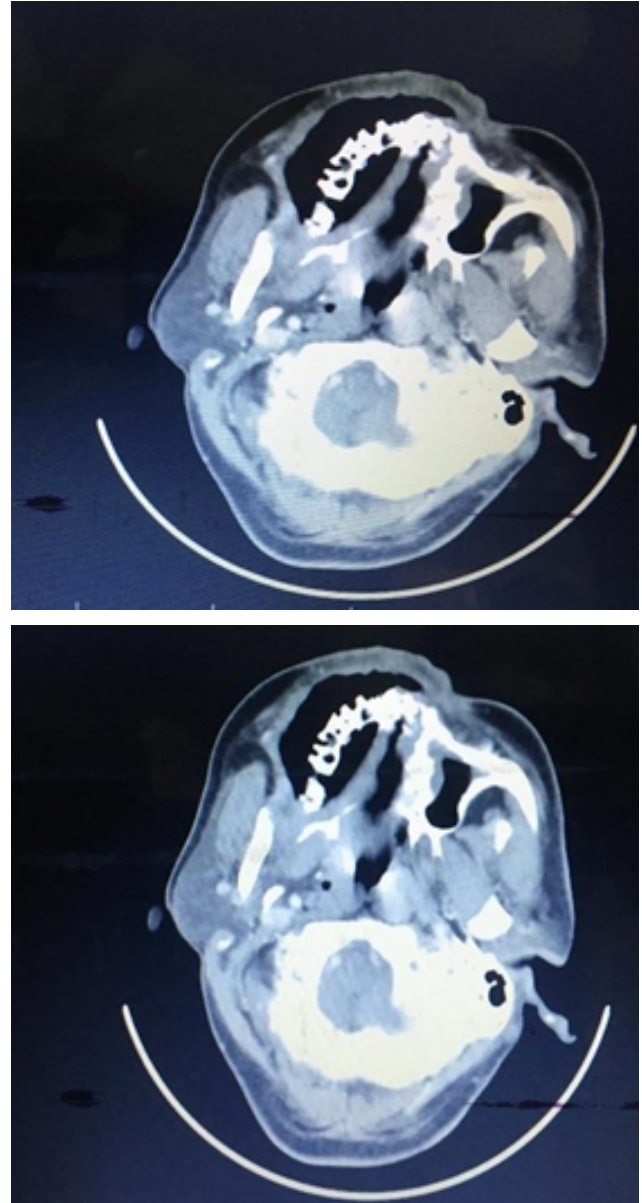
Axial view of the CT images
